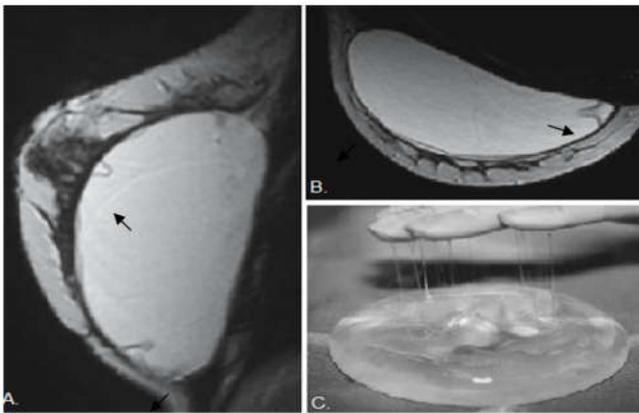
Leakage/minimally collapsed rupture imaged by MRI in a woman with silicone implants placed 10 years previously. (A) Sagittal fast spin echo T2-weighted MRI (TR 5700, TE 199, 4mm slice thickness) shows the noose sign (arrows). (B) Axial FSE T2-weighted MRI (TR 5700, TE 119, 4mm slice thickness) shows the sub-capsular line (curved arrows) and noose (straight arrow) signs. (C) Intraoperative photograph demonstrates the sticky contour of the leaking implant. No gross violation of the implant shell was found at surgery (Liberian and Berg, 2005).
